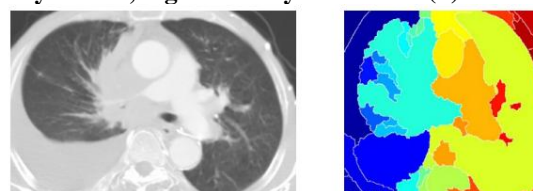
Image features Extraction stage is an important stage that uses algorithms and techniques to detect and isolate various desired portions or shapes (features) of a given image. To predict the probability of lung cancer presence, the following two methods are used: binarization and masking, both methods are based on facts that strongly related to lung anatomy and information of lung CT imaging.
